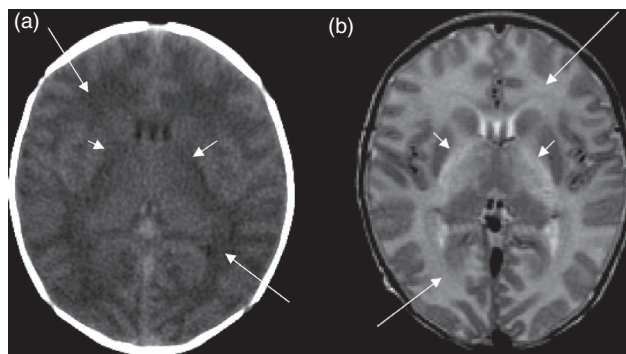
Maple syrup urine disease in neonate with globus pallidus (short arrows) and white matter (long arrows) edema on (a) axial CT and (b) axial T2 MRI.
